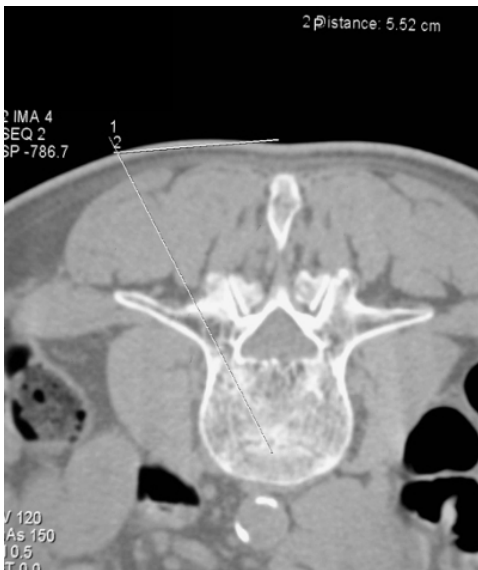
To facilitate the procedure, the approach should be visualized on a preprocedural CT scan (or axial MR imaging). The entry point and its distance from the midline (spinous process) can be measured on the preprocedural CT scan or MR films. A paramedian line lateral and parallel to the midline is drawn depending to the measurement done on the previous CT or MR scan (approximately 5 cm for lumbar level).
